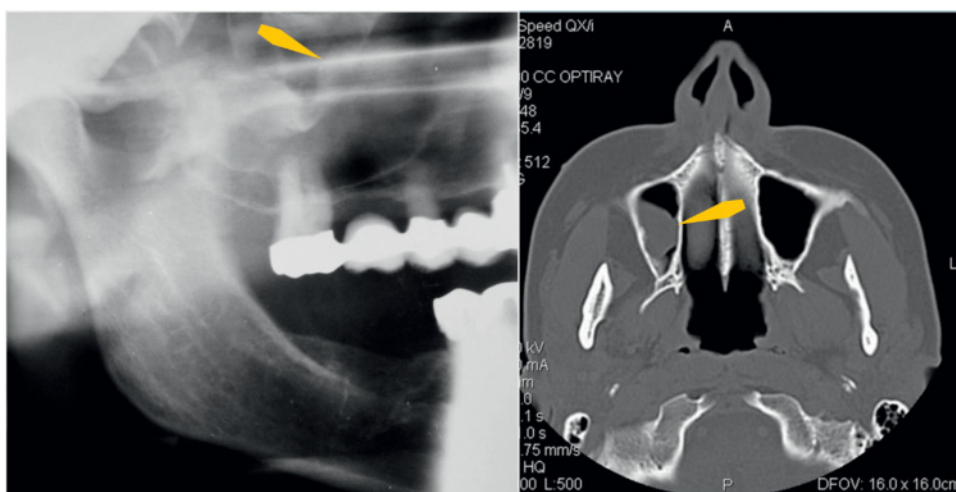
Comparison of pantographic radiograph (left) and cone beam computed tomography (right) images of a maxillary sinus “mucocoele” or pseudocyst of the lateral wall (arrows). The radiograph demonstrates a barely visible oval radiopacity, but the sessile, soft tissue nature of the lesion is readily visualized with cone beam computed tomography.
